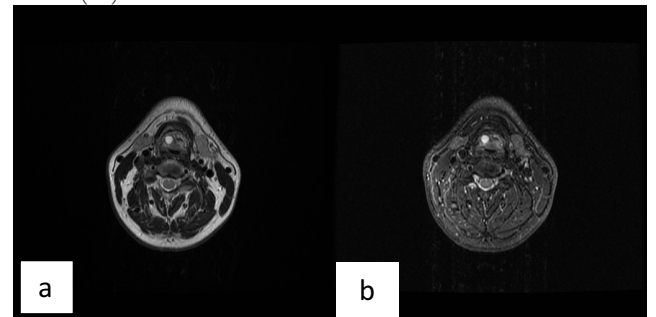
Ranula on T2-weighted axial scan (a) and fat-suppressed T2 axial scan (b).
